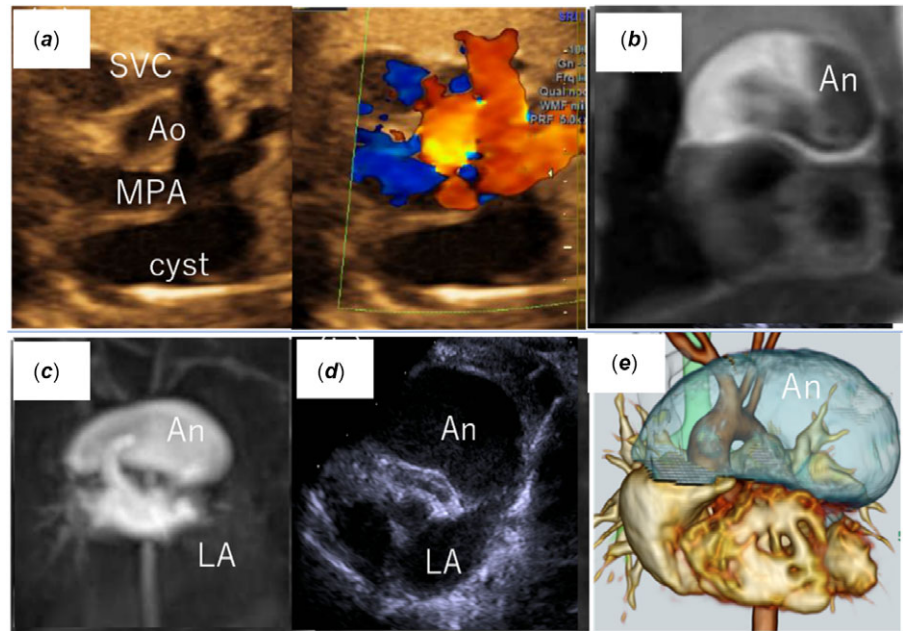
(a) Three-vessel view on fetal echocardiography at 34 weeks' gestation revealed a large cystic mass on the left side of the main pulmonary artery. (b) MRI confirmed post-natal enlargement of the aneurysm. (c) Contrast-enhanced MRI revealed that the aneurysm was connected to the left atrial appendage. (d) Transthoracic echocardiography view showing a large aneurysm arising from the left atrial appendage. (e) Left atrial appendage aneurysm (LAAA) on CT images. The LAAA extended anterosuperiorly to the heart, excluding the pulmonary artery. SVC = superior vena cava; AO = aorta; MPA = main pulmonary artery; An = aneurysm; LA = left atrium.
